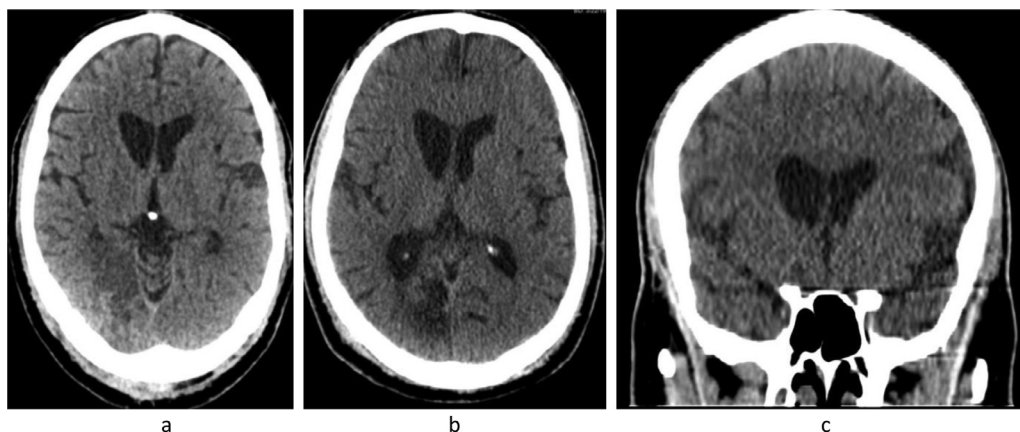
(A) Axial cut of plain CT brain - after 4 months. (B, C) Axial and coronal cuts of plain CT brain respectively—after 9 months follow-up: demonstrating ex-vacuo dilatation of the right lateral ventricle and cerebrovascular gliosis of the previously noted infarctions.
